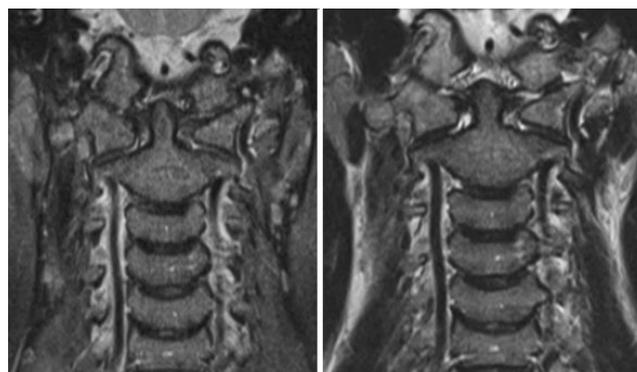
Follow-up magnetic resonance imaging showing the intact alar ligament.
